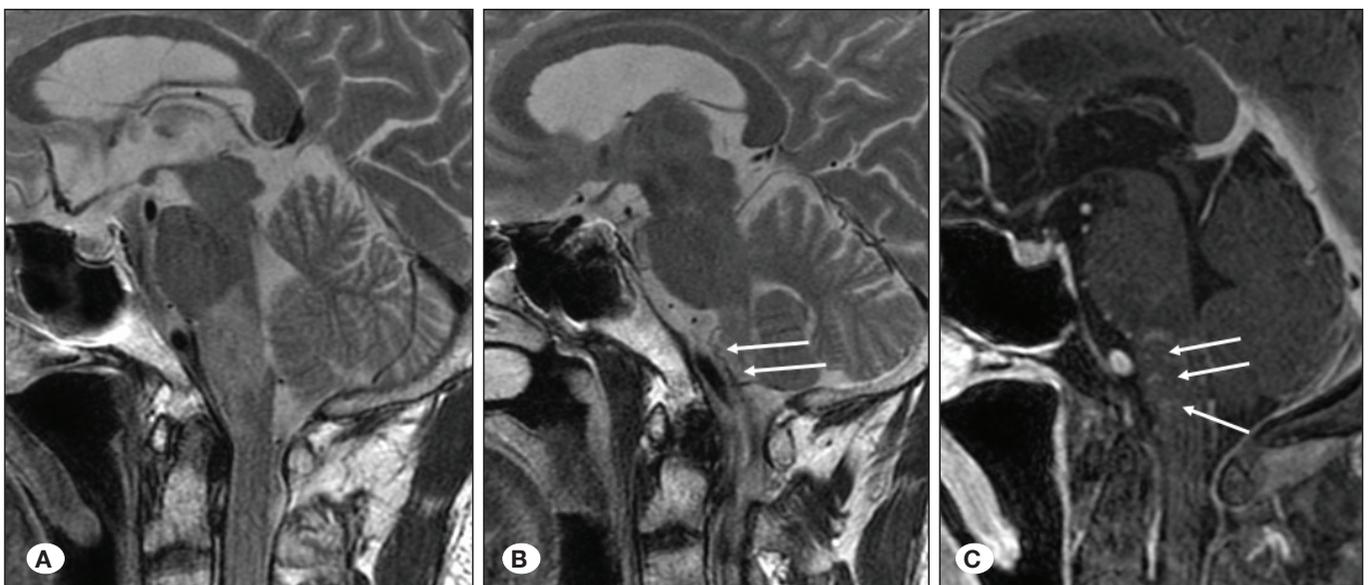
Magnetic resonance imaging (MRI) before surgery. A) Initial sagittal T2-weighted imaging (T2WI) showing a high-intensity area in the medulla oblongata. B) Sagittal T2WI MRI showing thin meandering vessels on the surface of the medulla oblongata (arrows). C) Sagittal T1WI with Gd enhancement showing a pool of contrast medium in the veins located around the medulla oblongata.
